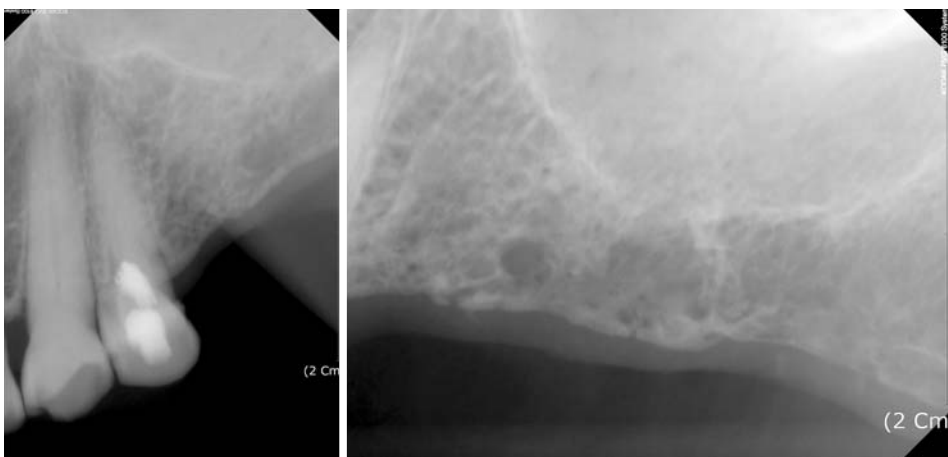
Intraoral radiographs show no periapical lesion on left maxillary first premolar. The maxillary sinus floor is intact.
